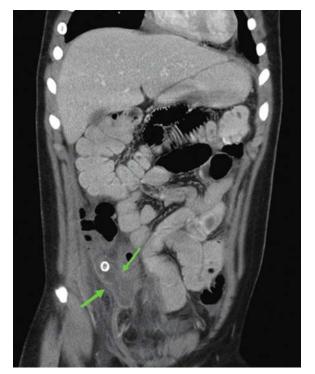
Coronal reformatted CT image produced after the administration of oral, rectal, and intravenous contrast shows dilated appendix *(arrows)* with a thick-ened enhancing wall and stranding of the surrounding fat. Note the round calcified appendicolith located near the orifice of the appendix.
